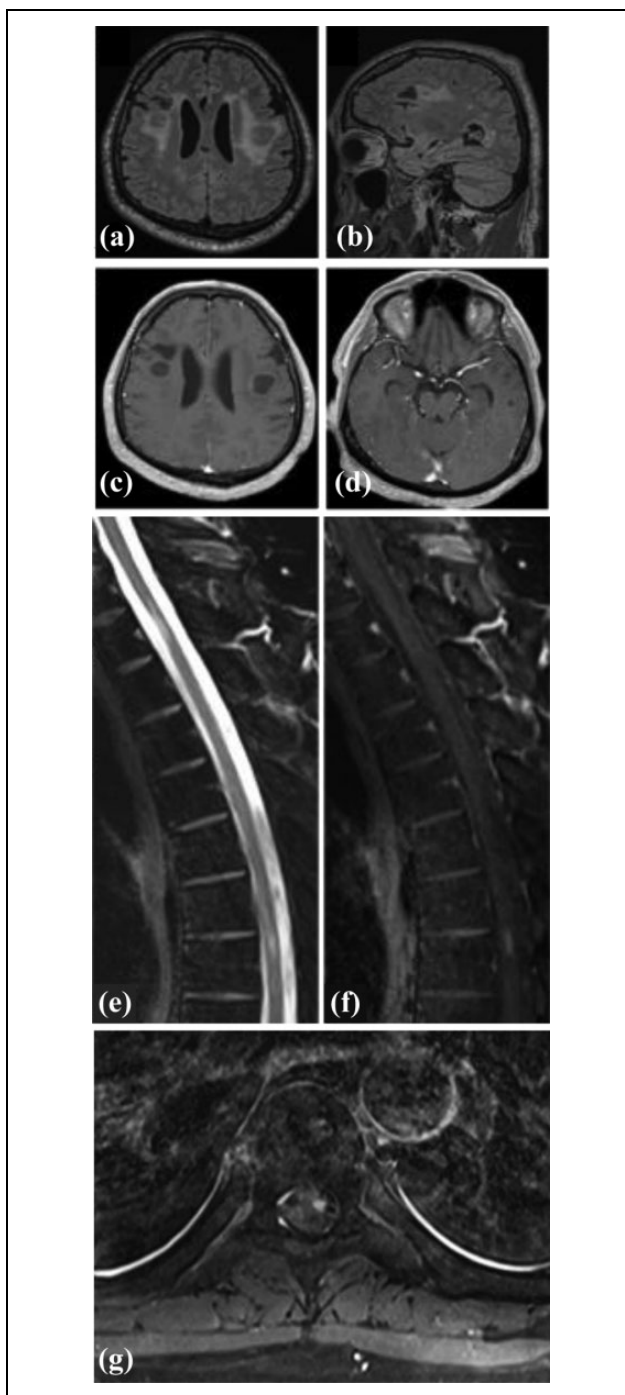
Brain and spinal MRI. 3-D FLAIR brain MRI sequence revealed (a) juxtacortical cysts with perilesional edema within corona radiata on both sides. (b) A cavity was located anterior to the right frontal cyst, and ovoid hyperintense lesions were present around the posterior horn of the right lateral ventricle. (c) The cyst walls exhibited gadolinium enhancement on a T1-sequence. (d) Another contrast-enhancing cyst was found adjacent to the left medial temporal gyrus. (e) On spinal cord MRI, T2-hyperintense lesions were seen at the level of T1 and T6–7, (f) one of which showed gadolinium enhancement (T6–7). (g) The enhancing lesion at the level of T6–7 was lateralized to the left. 3-D FLAIR: 3-D sagittal Fluid Attenuated Inversion Recovery; MRI: magnetic resonance imaging.
